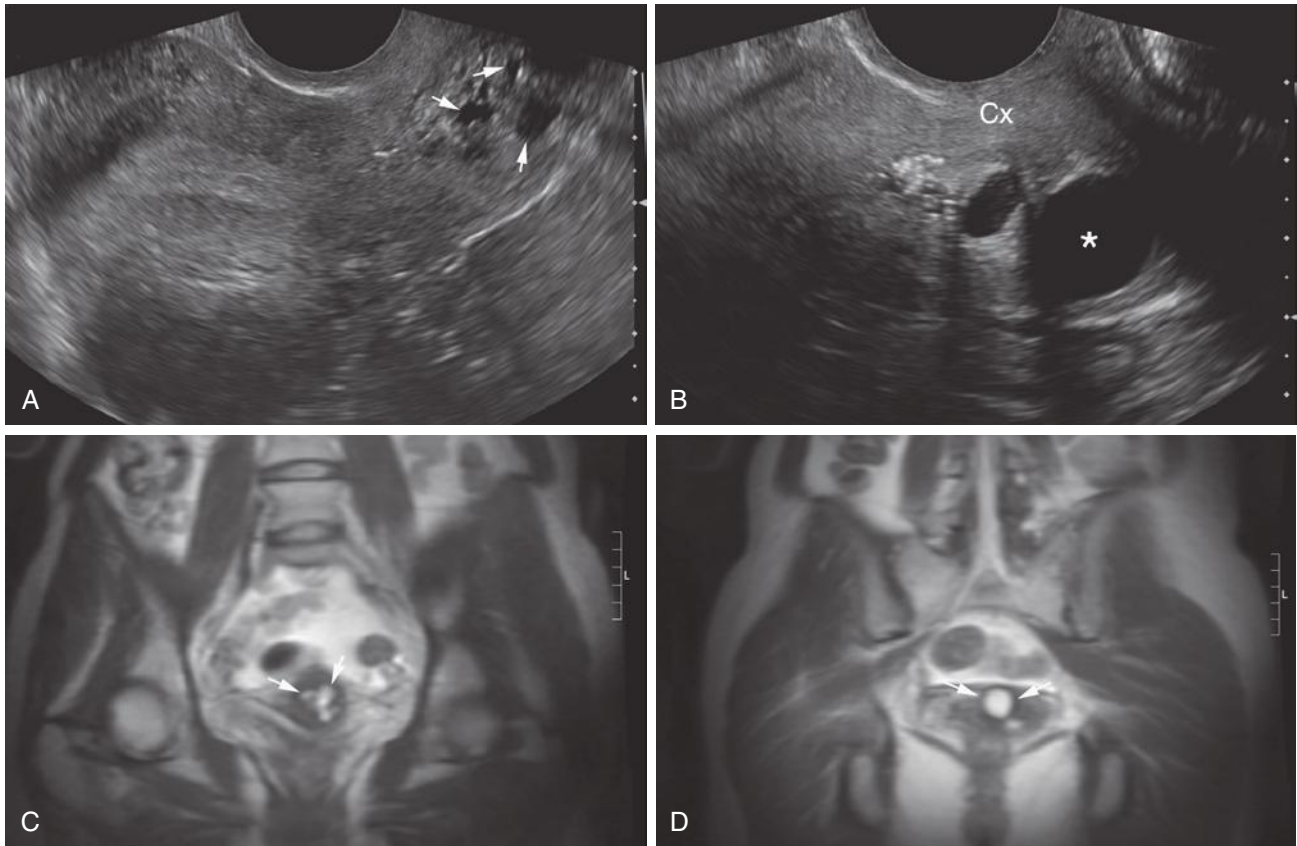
Longitudinal transvaginal sonogram through the cervix of a nongravid uterus. A and B, Multiple nabothian cysts (*arrows*) are seen in the cervix (Cx). At times these cysts can be quite large (*asterisk*). These retention cysts are quite common and should not be confused with low-implanted gestational sacs or other abnormalities. C and D, Two coronal T2-weighted magnetic resonance images through the cervix demonstrate multiple, round, T2-weighted hyperintense structures compatible with nabothian cysts (*arrows*).
